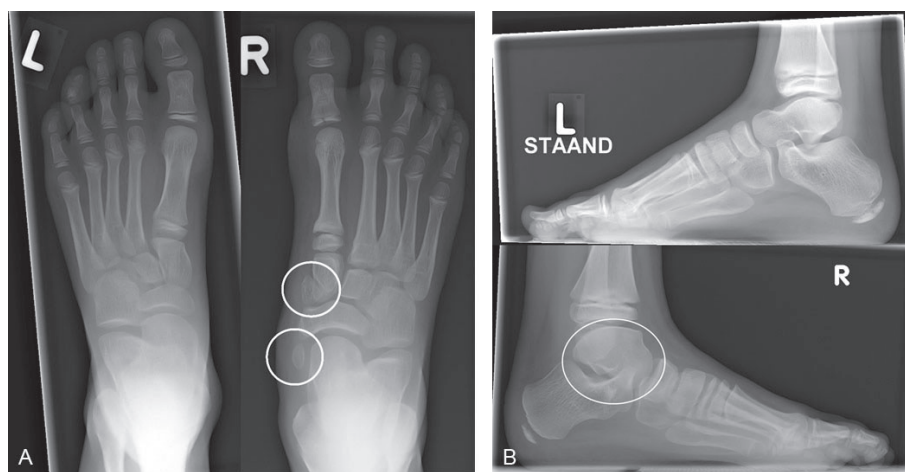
Radiograph of the lower limb at the age of eight years old.
